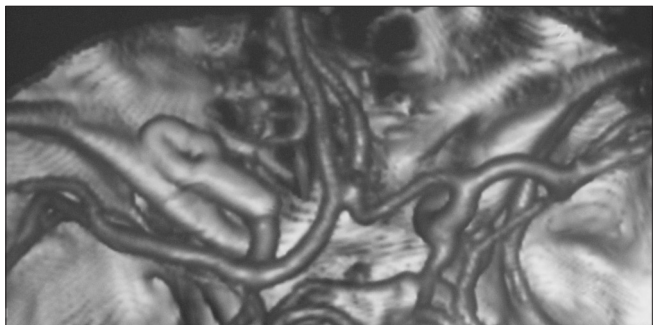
Angio-CT with 3D reconstruction showing the left ophthalmic artery aneurysm
